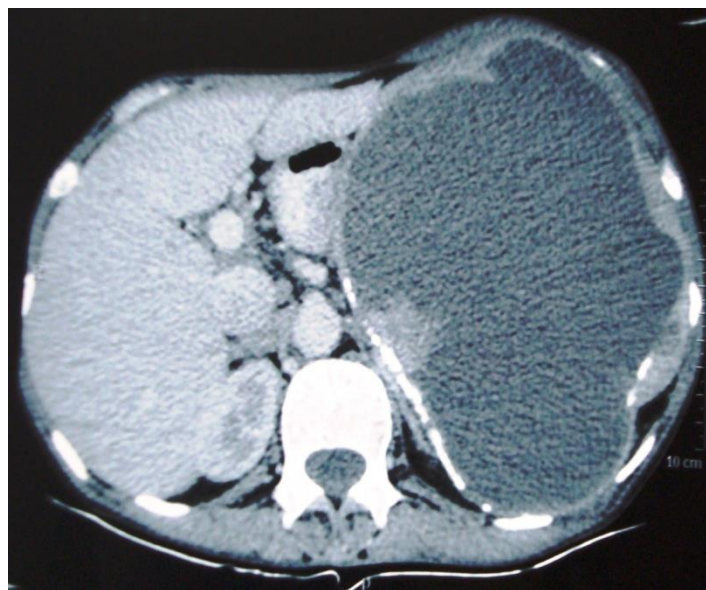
CT scan shows enlarged spleen with a large cystic lesion
